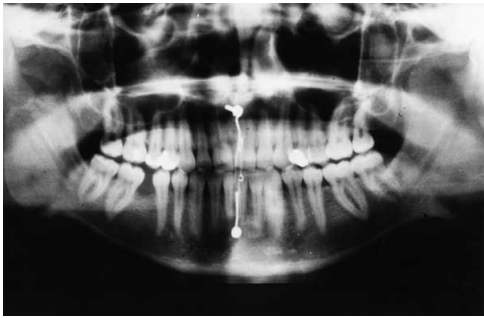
X-ray OP postoperative
